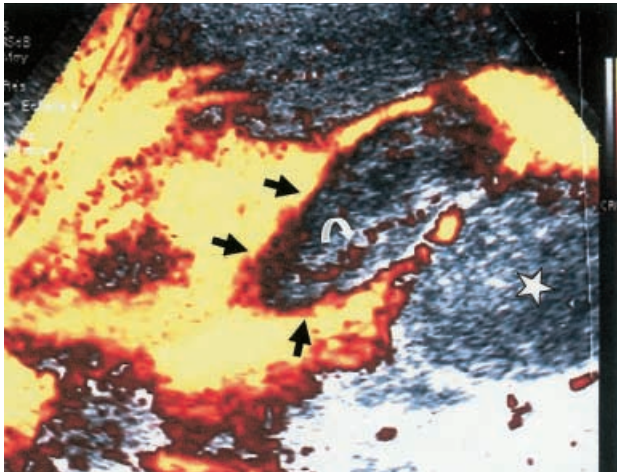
Renal cell carcinoma with inferior vena cava invasion. Power Doppler US (longitudinal scan) of the inferior vena cava shows tumor thrombus (*straight arrows*) with color flow signal related to tumor vascularity (*curved arrow*). Enlarged node is also seen posterior to the vena cava (*star*)
